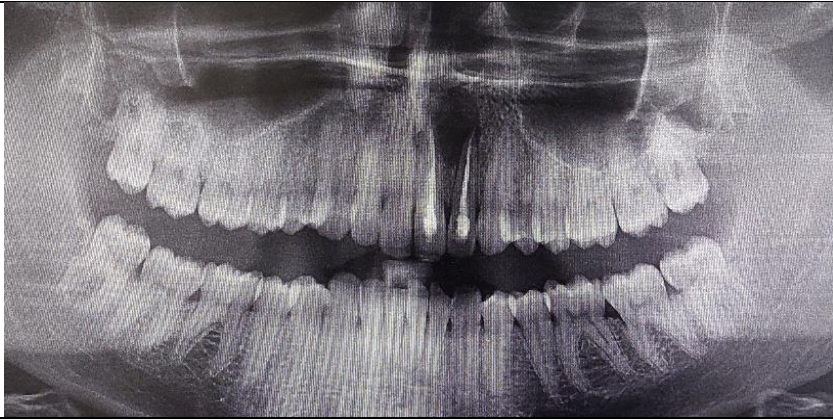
Preoperative radiography : large radiolucent image in the apical area regarding 21-22
